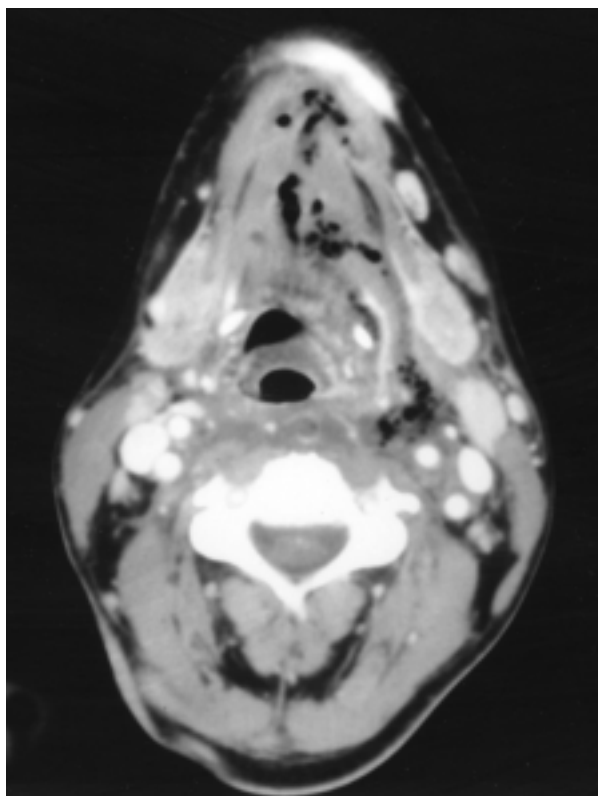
Computed tomography scan of patient 1.
